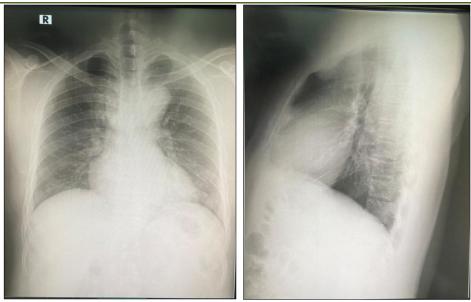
Anteroposterior and lateral chest radiograph showing lytic lesion adjacent to the sternal bone
